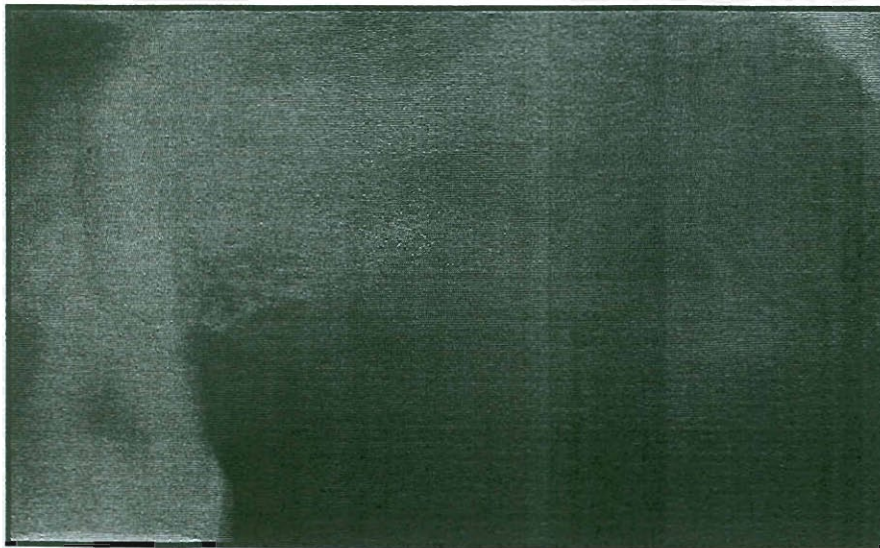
Six-month postoperative radiograph revealing the augmented sinus and demonstrating an increase in available bone for the placement of dental implants.
